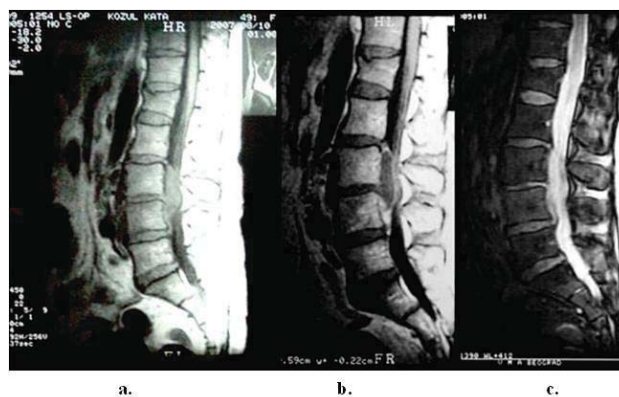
Magnetic resonance imaging of the spine: T1W sequence with and without contrast (a,b); T2W FSE sequence (c) – expansive formation of the spinal canal at the level of L3/L4 vertebral bodies
